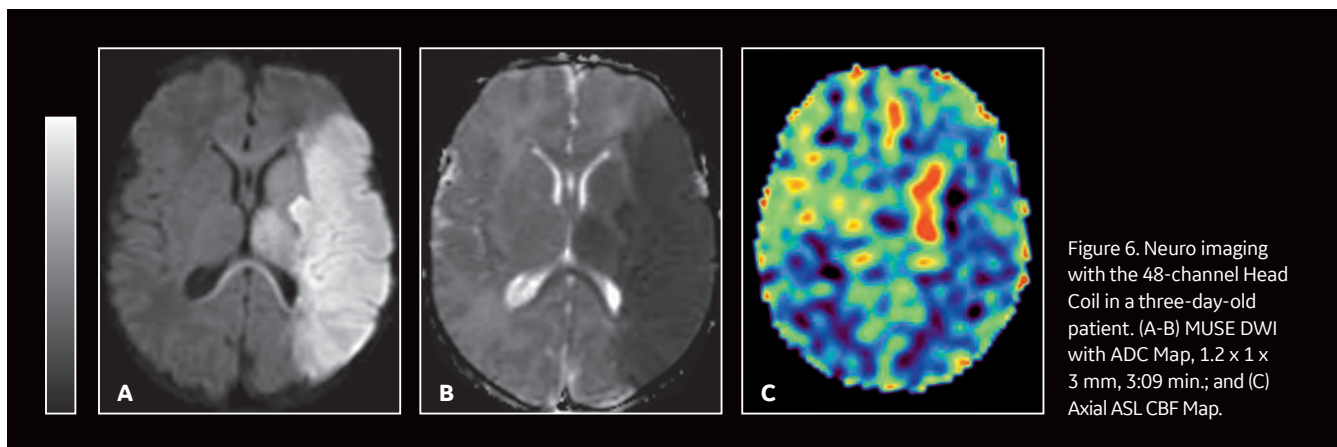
Neuro imaging with the 48-channel Head Coil in a three-day-old patient. (A-B) MUSE DWI with ADC Map, 1.2 x 1 x 3 mm, 3:09 min.; and (C) Axial ASL CBF Map.
